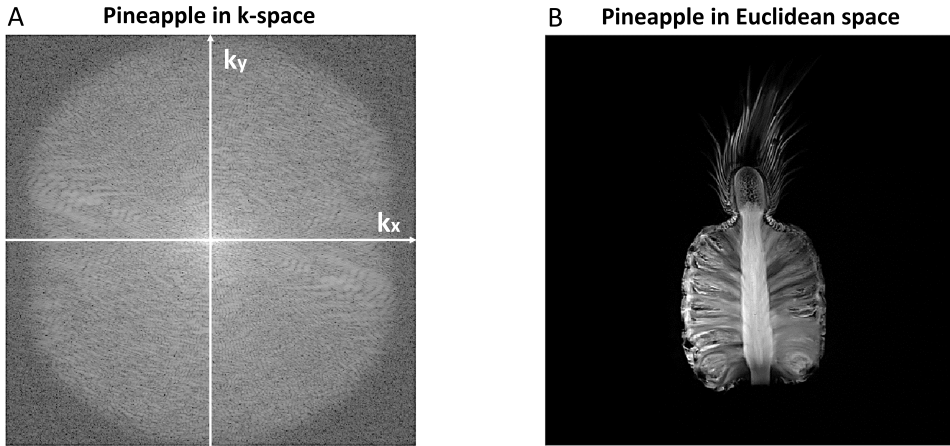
k-space (A) stores the spatial frequency representation of a pineapple along the k_x and k_y axes. The MR image (B) is a more familiar spatial representation of that same pineapple.
